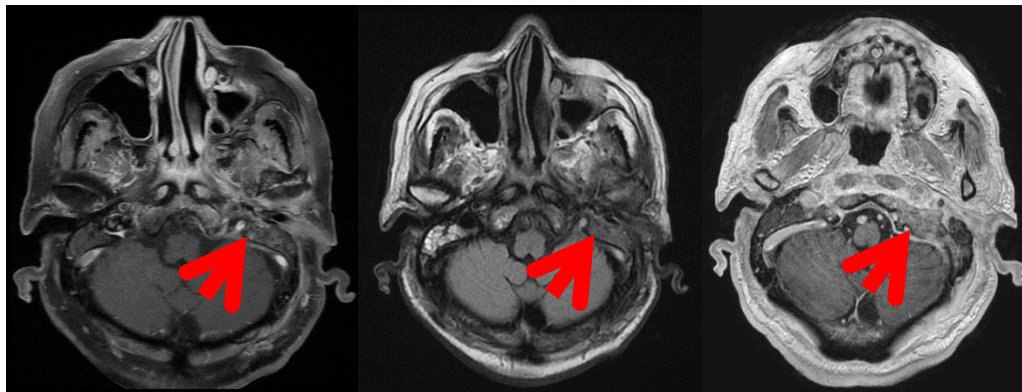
MRI of head without and with contrast medium images
